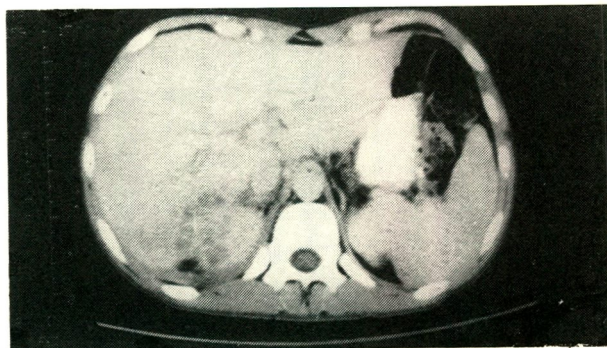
a. CT scan cut, showing the non-homogenous upper pole of the right kidney. The multiple lucent areas indicating the abscess, also seen.
